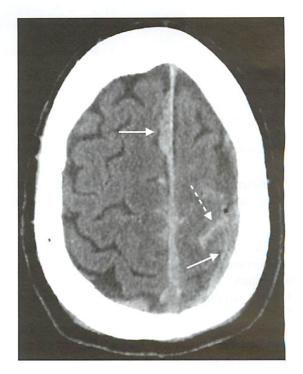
Initial non-contrast CT of the brain. An axial CT image in soft tissue algorithm shows left frontal subarachnoid hemorrhage (dotted arrow) and right parafalcine and left superior convexity subdural hemorrhage (solid arrows). Note the absence of contusion evident in the superior frontal brain parenchyma.
